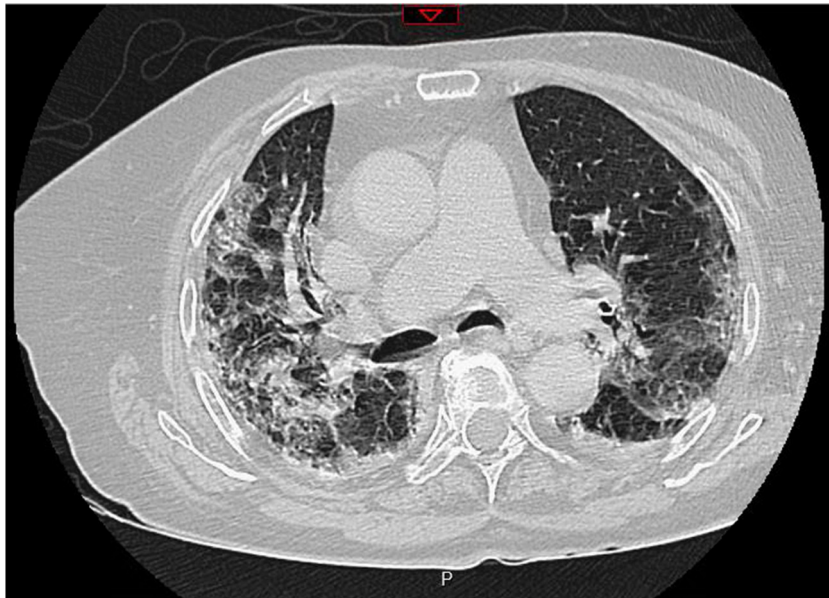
Thoracic computed tomography (CT) scanner (transverse computed axial) of index resident case. An 80-year-old woman with fever and shortness of breath. CT scan showed ground glass opacities with septal thickening representing a “crazy paving” pattern that predominates in peripheral lung fields (degree of lung involvement between 25% and 50%) highly suggestive of COVID-19.
